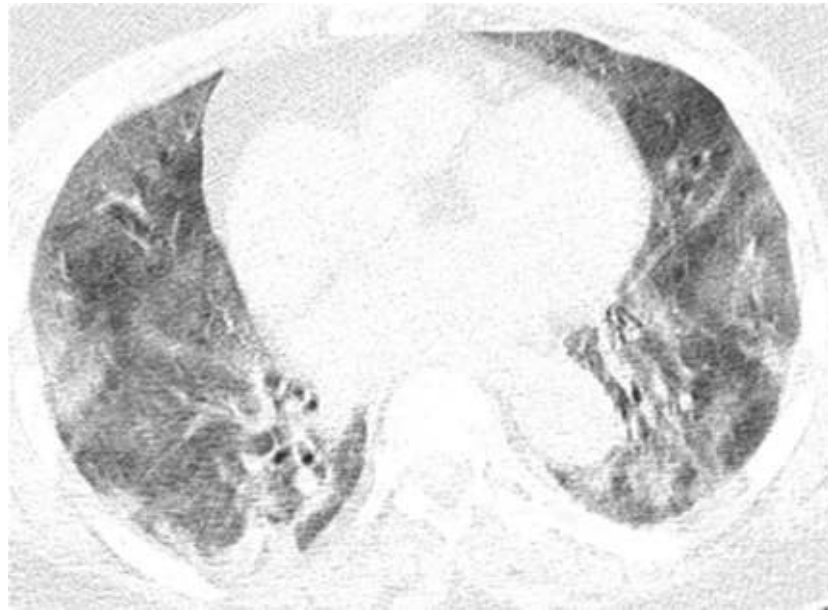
Four days later, pulmonary CT in the Case 10 patient showed dimensional extension of the previously described lesions, with a tendency of small-holding. In conclusion, pulmonary lesions of SARS-CoV-2 type (with the tendency of consolidation) in dimensional progression, with a severity score = 22 (20 for the previous examination), which corresponds to a severe disorder.
